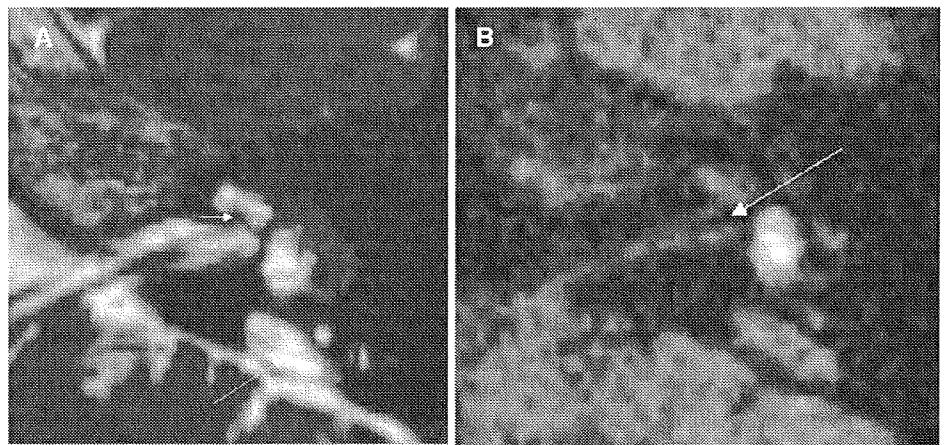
A 27-year-old man had enlarged endolymphatic duct and sac syndrome (EEDS) and vertigo. A On 3D-CISS, an enlarged endolymphatic sac (*long arrow*) and slightly small but normally shaped modiolus (*short arrow*) can be seen. B On 3D-FLAIR after intratympanic injection of Gd-DTPA, no enhancement can be seen in the CSF of the IAC fundus (*arrow*)
